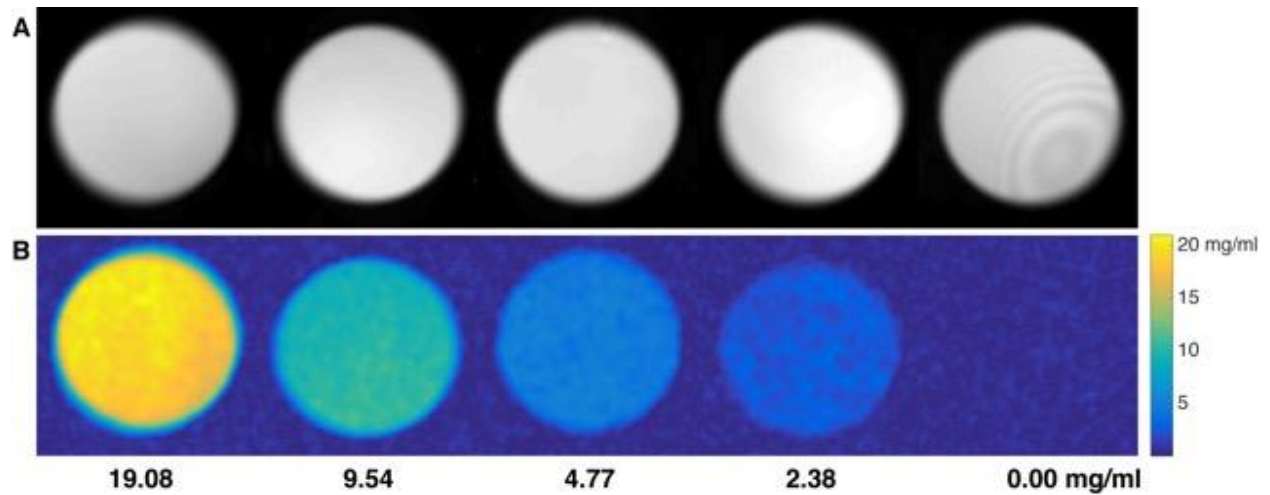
Diffusion-weighted spin-echo MR images of 8PEGA obtained with $b = 10^8 \text{ s/m}^2$ (A) and $b = 10^{10} \text{ s/m}^2$ (B). The 110 M water proton signal dominates conventional MR images as seen in (A) but is suppressed by a factor of 10^{-10} by imaging at $b = 10^{10} \text{ s/m}^2$. The diffusion constant of 8PEGA was measured by stimulated echo pulsed field gradient NMR at 25 °C to be
